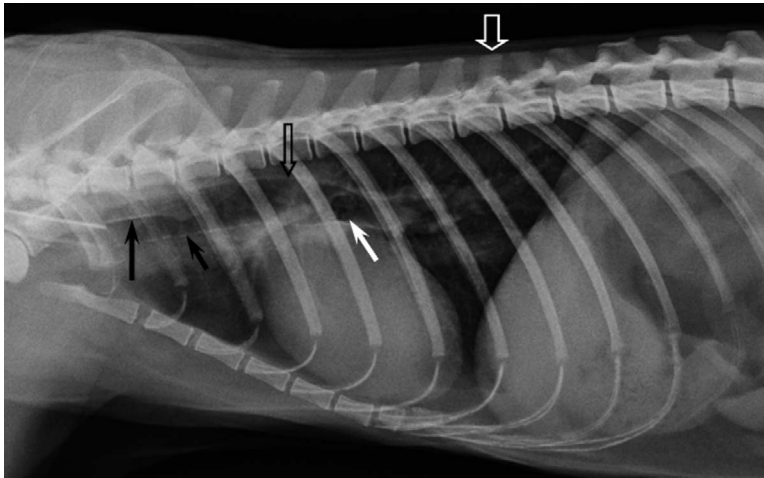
Right lateral thoracic radiograph of a 10-yr-old male (5.5-kg) red panda. Note the short spinous processes of the thoracic vertebrae and anticlinal thoracic vertebra No. 10 (open white arrow). The sternum is fairly straight, with eight sternbrae. The trachea with mineralized cartilage rings (short black arrow) is aligned almost parallel to the thoracic spine and diverges from the thoracic spine from thoracic vertebra 6 (open black arrow) caudally. Note also the superimposition of the caudal borders of the scapulae to the trachea (long black arrow) and clearly visible carina in the fifth intercostal space (white arrow). The cardiac silhouette is ovoid and obliquely positioned, occupying not more than 3.5 intercostal spaces.
